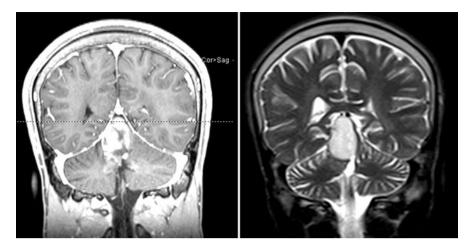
MRI on admission (left) compared to 3 months prior (right) showed postsurgical changes of suboccipital craniectomy with unchanged mass effect on the remaining posterior fossa structures and unchanged lateral, third, and fourth ventricle sizes. Mild interval enlargement of solid enhancing residual/recurrent tumor in the superior vermis, compared to 6 months prior. No new FLAIR signal abnormality. Gliosis from prior treatment is seen
